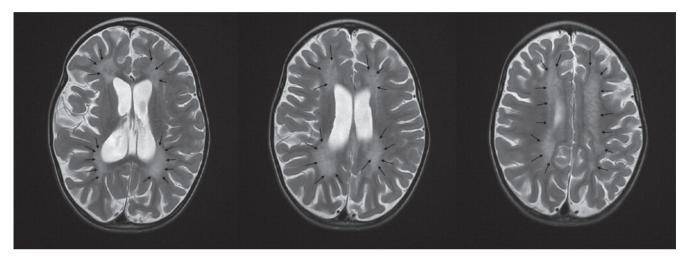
MRI of endocranium revealed bilaterally symmetric, increased signal intensity of the white matter. Tigroid pattern of the white matter with linear normal intensity was present within the white matter that has been spared from the demyelination.
